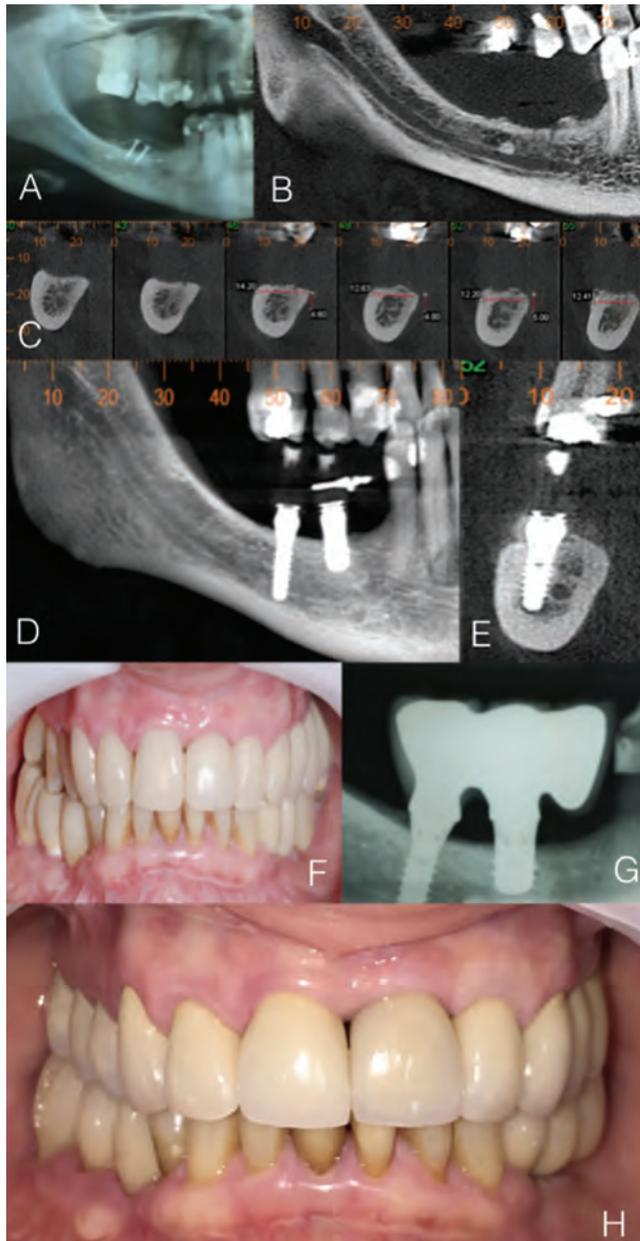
[A] Bone block graft fixation screws. An attempt at vertical gain that did not work; [B,C] Panoramic and transaxial CBCT images of the mandibular canal (MC) before the implants; [D] Implant 31 appears to have transfixed the IAN; [E] The implant 31 passes buccally to the MC; [F] Fixed Provisional Restorations (FPR). [G] X-ray of Metal-Ceramic bridge; [H] Definitive restorations.
